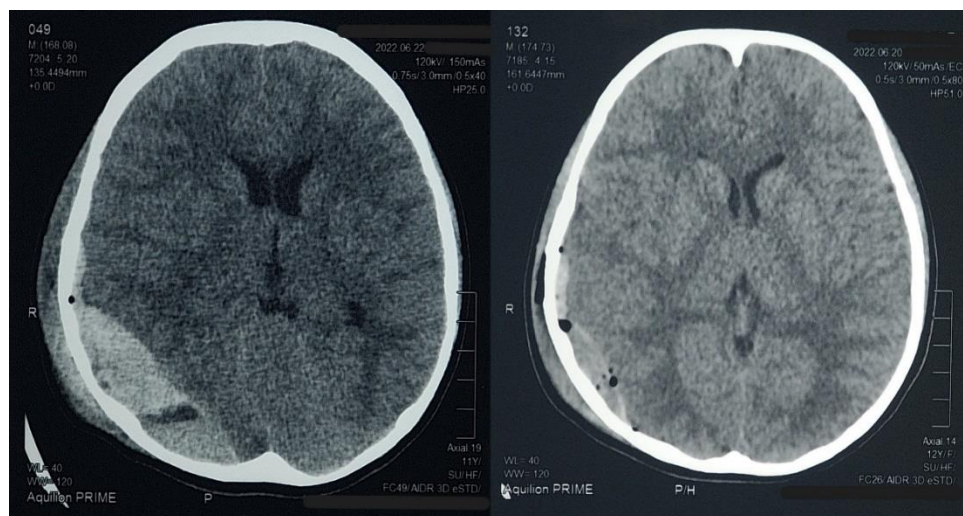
CT scan (right) showed epidural hemorrhage in the temporo-occipital region dextra carried out based on the nurse's report. Increased blood volume compared to initial head CT scan (left).
